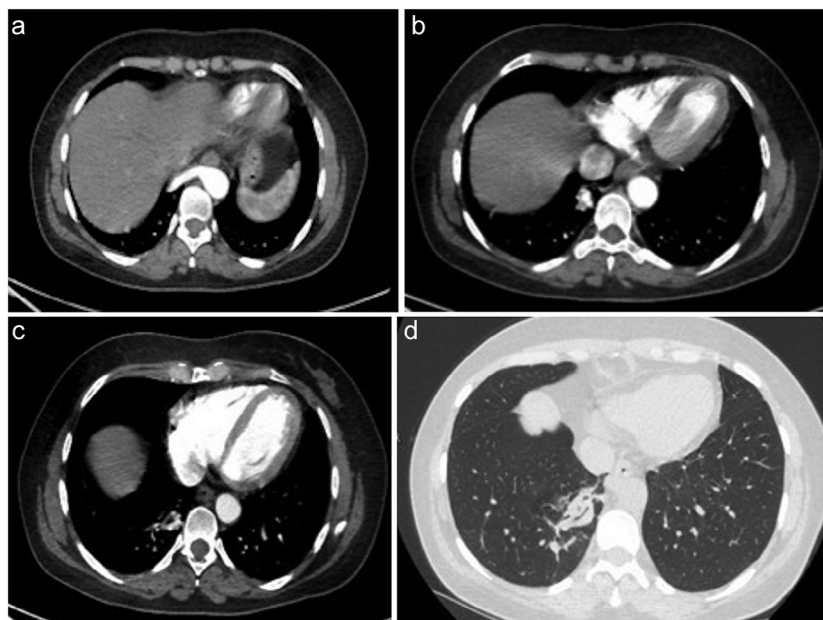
(A, B, C, and D) Pre-embolization chest CT examination (arterial phase) on axial planes showing the presence of a large systemic anomalous arterial branch (A) emerging from the right anterolateral wall of the descending thoracic aorta and subdivided in further abnormal arterial branches (B, C) resulting in arteriovenous malformation in the basal medial lobe of the lower lobe of the right lung. The arteriovenous malformation is surrounded by thickened lung parenchyma and areas of “ground glass” (D). CT, computed tomography.
